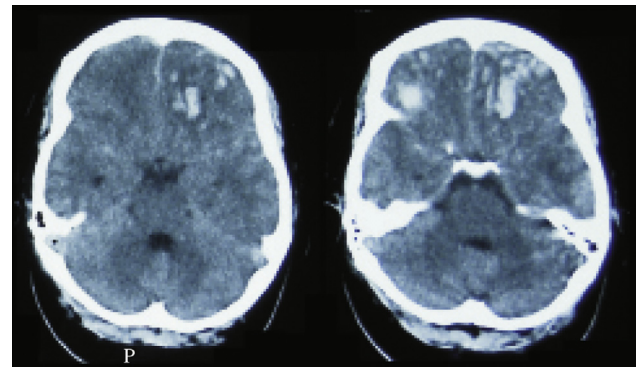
Brain plain CT scan of a young aged female with road traffic accident showing bilateral frontal contusion.
